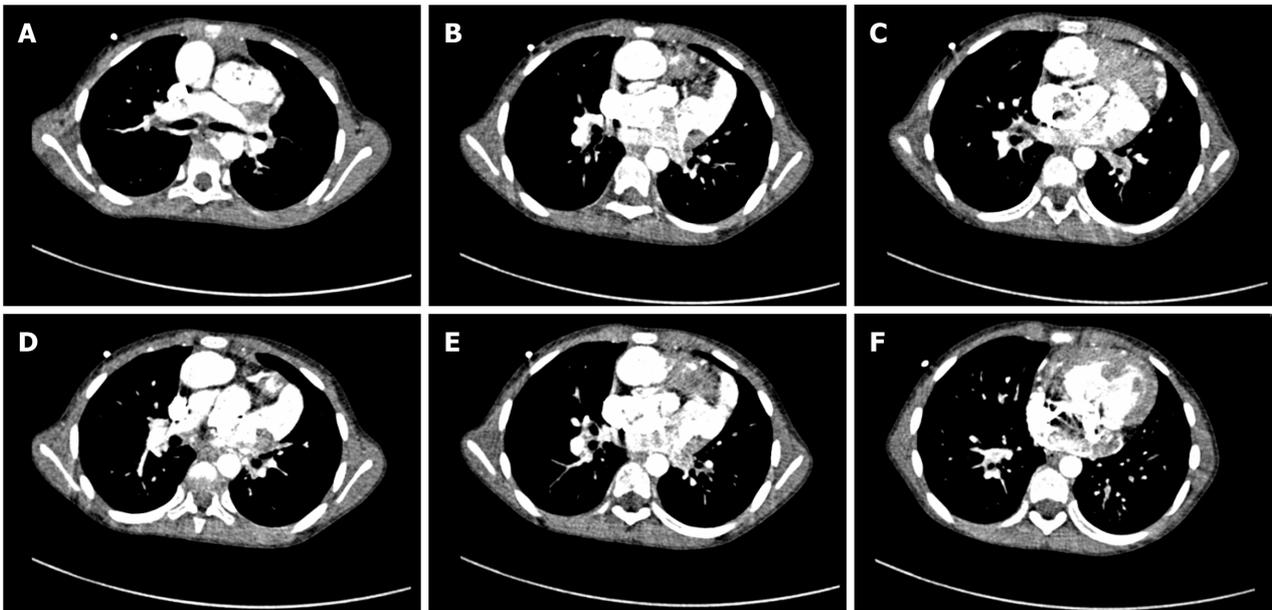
Chest computed tomography. A-C: Both the aorta and pulmonary artery were connected to the right ventricle, and the aorta was anterior to the pulmonary artery; D-F: Significant right ventricular enlargement, atrial septal defect (width, 1.4 cm), and ventricular septal defect (width, 1.7 cm).
